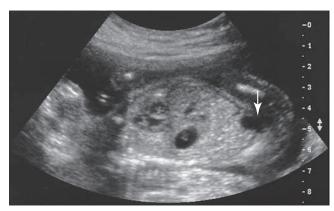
Sagittal sonogram of the fetal body.
